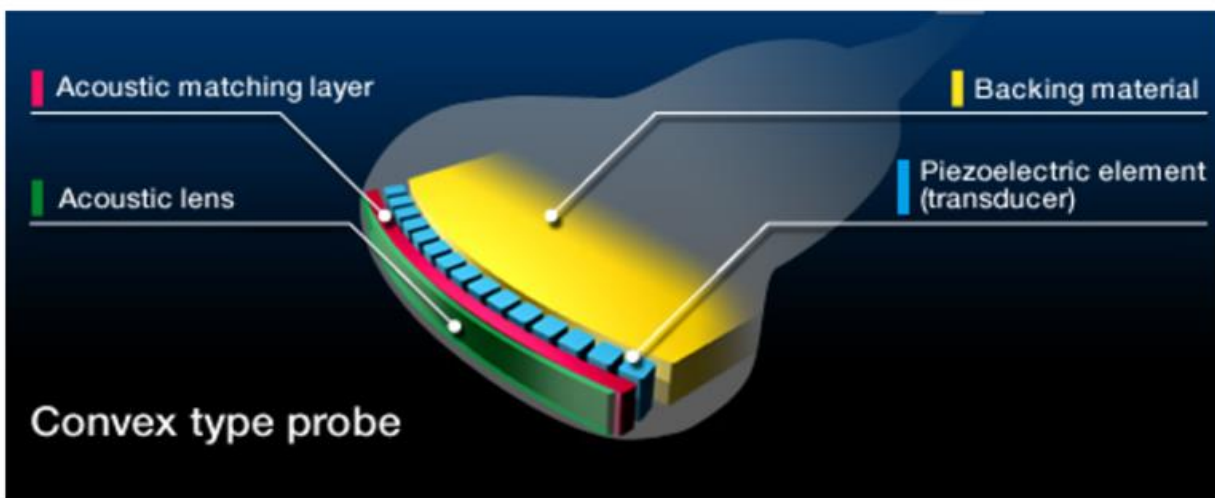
Convex Array Ultrasound Probe
